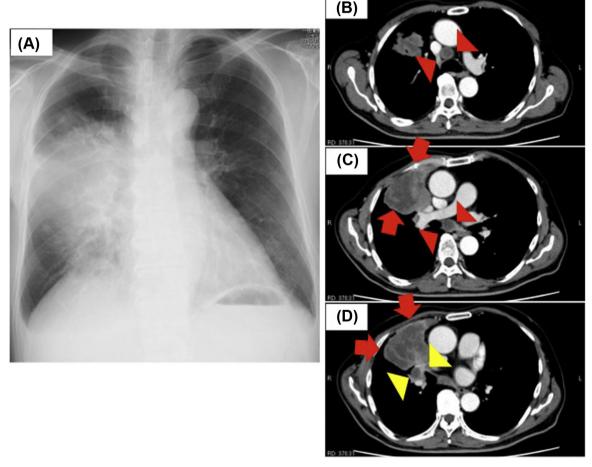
Panel A: Chest X-ray revealed the right tumor and the infiltration shadows around the tumor. Panel B, and C and D: Chest CT revealed a pulmonary tumor(C and D; red arrows), hilar (D; yellow arrowheads) and mediastinal (B and C; red arrowheads) lymphadenopathy is enhanced by contrast medium.
